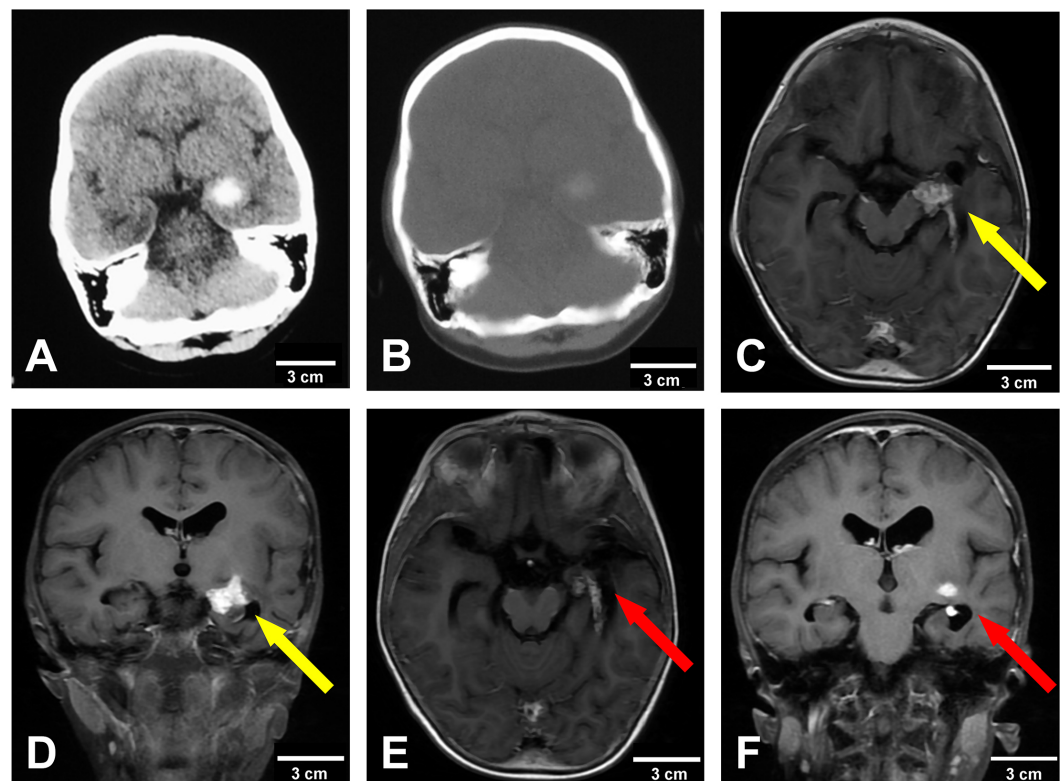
Radiographic images of the tumor. (A,B) Preoperative computed tomography (CT) scan demonstrated a left temporal lobe occupation with mild calcification. (C,D) Twelve months after operation, the magnetic resonance imaging (MRI) scan revealed a medial temporal lobe mass (17 × 14 mm) with heterogeneous contrast enhancement (yellow arrows). (E,F) After 9 cycles of temozolomide and irinotecan treatment, the tumor shrank in size (red arrows). The scale bars represent 3 cm.
